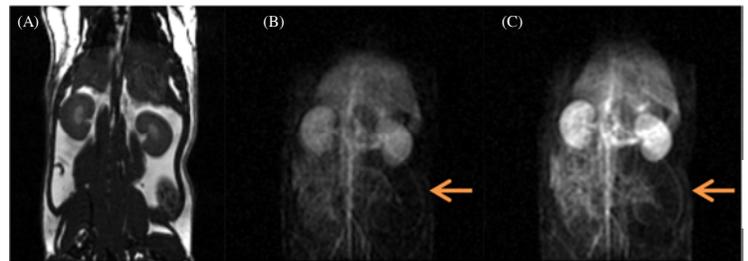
In vivo image of ¹H MRI (A) and HP ¹³C urea with CFA (B) and VFA (C).
